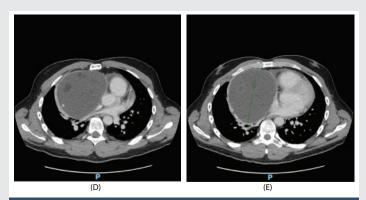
The mass has a cranio-caudal dimension of 13 cm, deviating and compressing the main mediastinal strictures. B: CT scan image demonstrating the pericardial effusion. C: The mediastinal mass compressing and deviating the heart and the large vessels.
